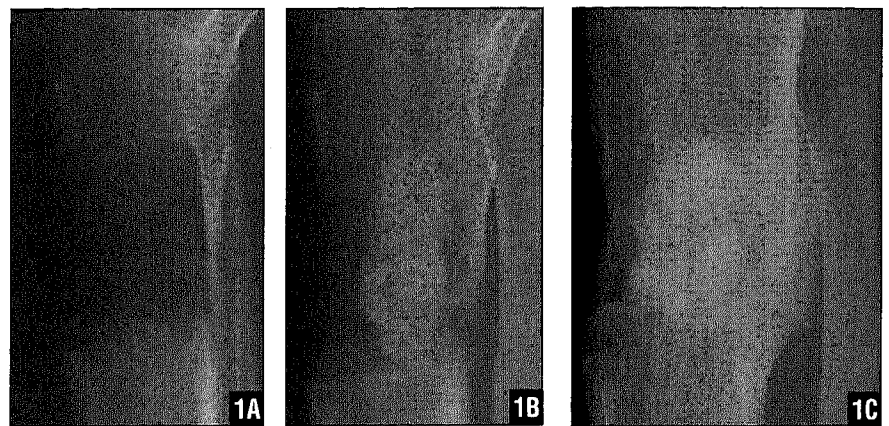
Radiographs of the left tibia in a 25-year-old patient who underwent bilateral tibial lengthening with an external fixator. At the end of the lengthening, given the inadequate distractional osteogenesis, platelet gel and hydroxyapatite were inserted (A) while maintaining the fixator in situ (B). Six months postoperatively, reconstruction of the lengthened bone, initial cortical formation of the graft, and disappearance of the granular weave of the hydroxyapatite were evident (C).
